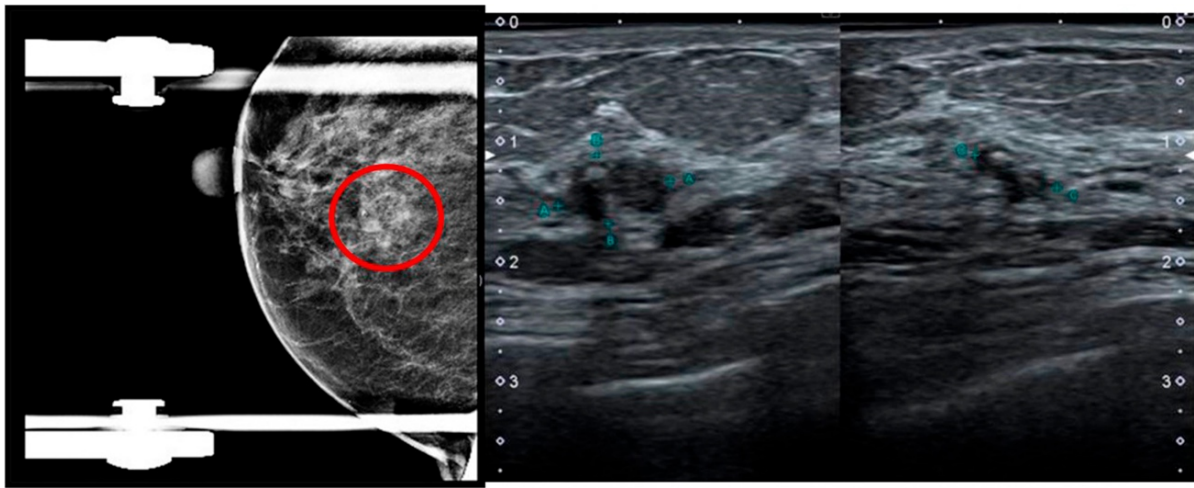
Mammography (left) and ultrasound (right) demonstrating a 9 mm hypoechoic and irregular nodule in the lower internal quadrant of the right breast.
